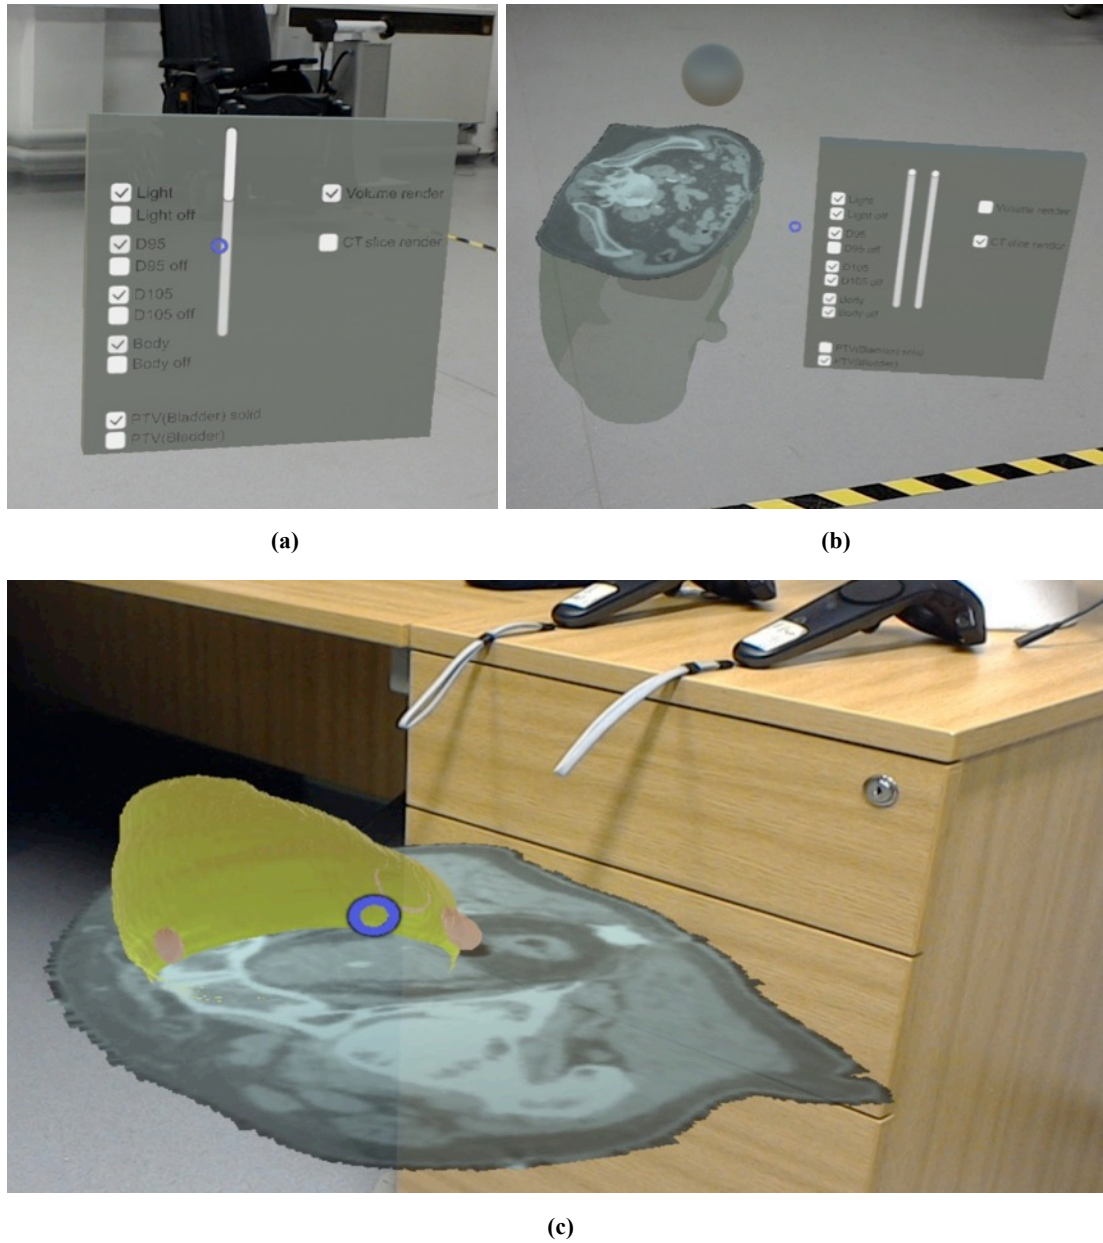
RAD-AR for plan evaluation. (a) User controls to switch on/off display of AR elements (light, isodose surfaces, PTV), scroll through CT slices. (b) User controls and patient body outline with scrollable CT slice. (c) RAD-AR rendering of a CT slice and PTV (bladder) surface.
